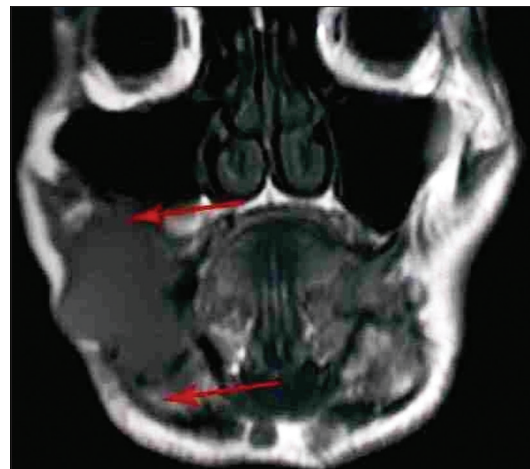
Magnetic resonance imaging image of a patient (coronal view)
